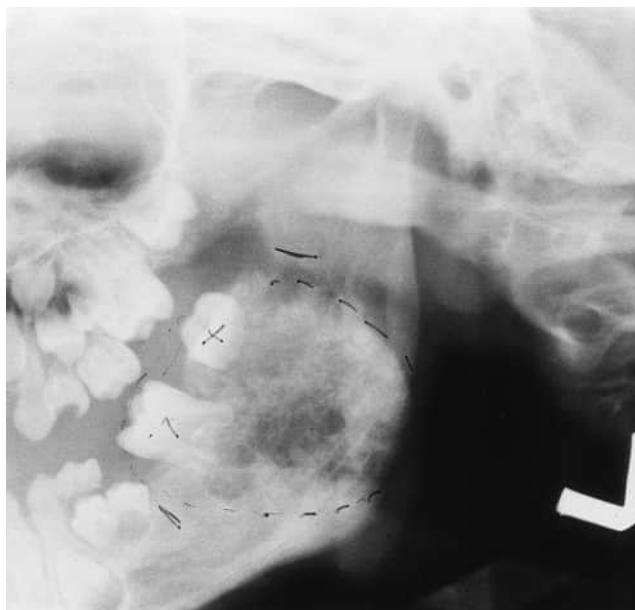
Radiograph of the same patient as in Fig. 5.43 with Ewing's sarcoma involving the left angle of the mandible. Notice the mottled radiolucent appearance. (Courtesy Drs. Richard L. Miller and William Epstein.)
